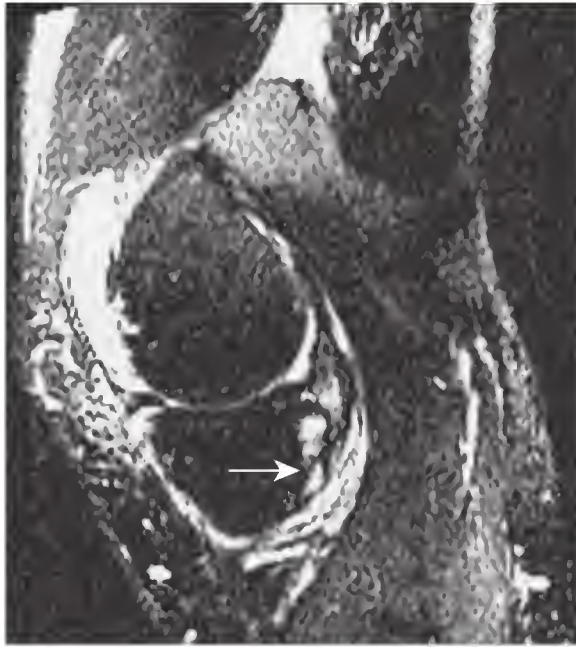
Magnetic resonance image (MRI) of a patient with psoriatic arthritis who clinically had a swollen knee. On MRI, clinically unrecognized enthesitis at the semimembranosus insertion is evident (white arrow). The enthesitis is recognizable by the presence of bone edema. However, not all regions of enthesitis in synovial joints, as elsewhere, have associated bone changes, which makes synovial joint enthesitis difficult to define, even on imaging.
